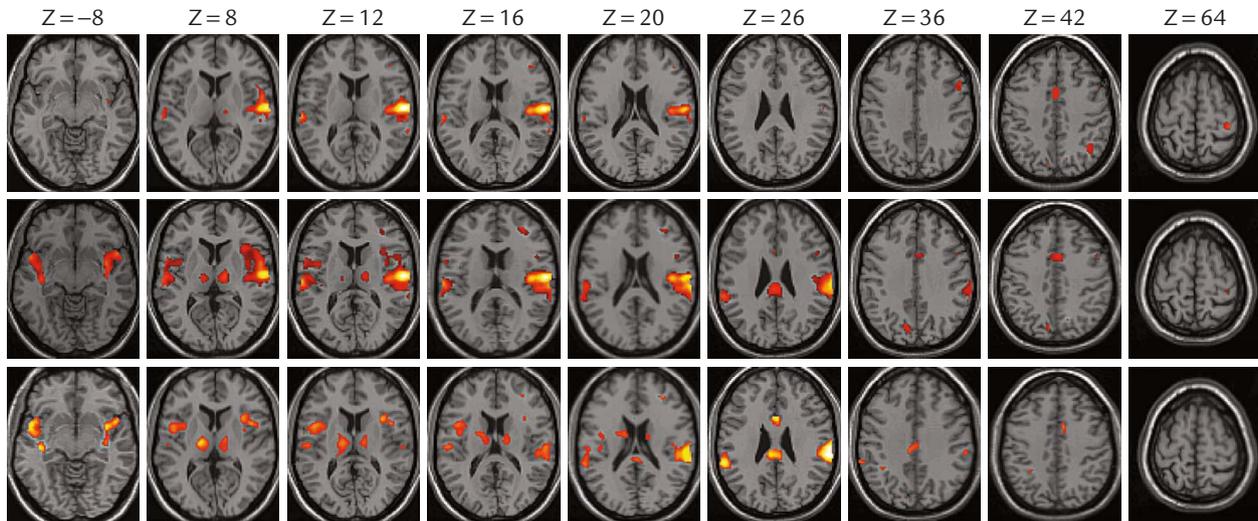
Blood oxygenation level dependent functional magnetic resonance imaging shows responses to non-painful intramuscular electrostimulation (IMES; top row), painful IMES (middle row) and painful – non-painful IMES (bottom row). The Z-coordinate denotes the axial section in the superior-inferior position relative to the commissural line (given in millimeters; positive = superior). Reproduced with permission from Reference 40.
